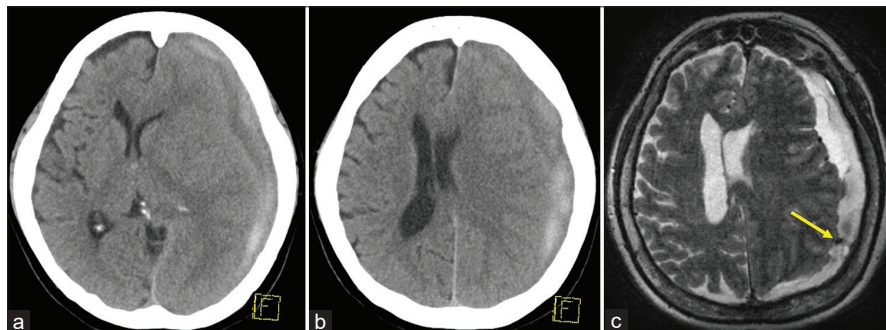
Axial computed tomography scans (a and b) and T2-weighted magnetic resonance imaging (c), performed on post hospitalization day 14, showing a considerable enlargement of the subdural hematoma with the nodular lesion better circumscribed from the surrounding hematoma (c, arrow).
